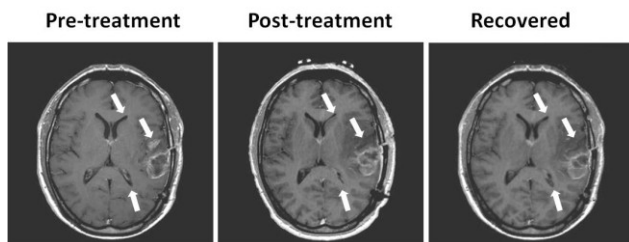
Real MRI clinical case images elastic registration.
